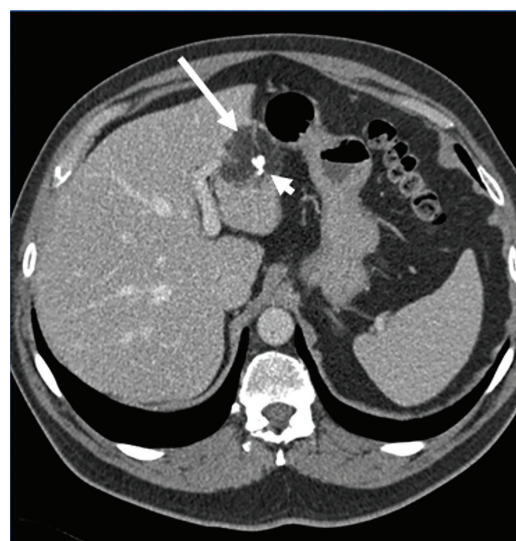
Axial contrast-enhanced computed tomography in the portal venous phase shows a left hepatic lobe mass (long white arrow). The mass was found to represent a teratoma. It is predominantly fatty with peripheral nodular calcifications (short white arrow).
